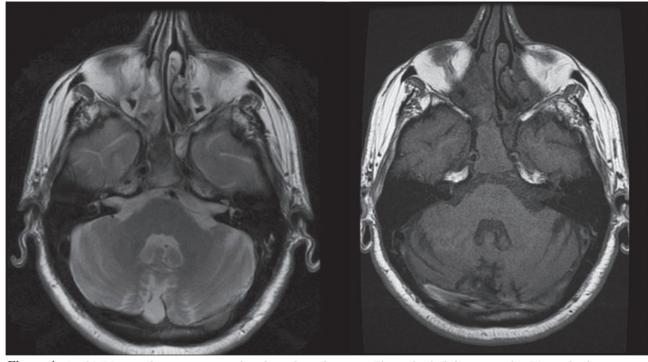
Axial MRI sinus showing near signal void in sphenoid sinus on T2-weighted (left) compared to T1-weighted images (right)
